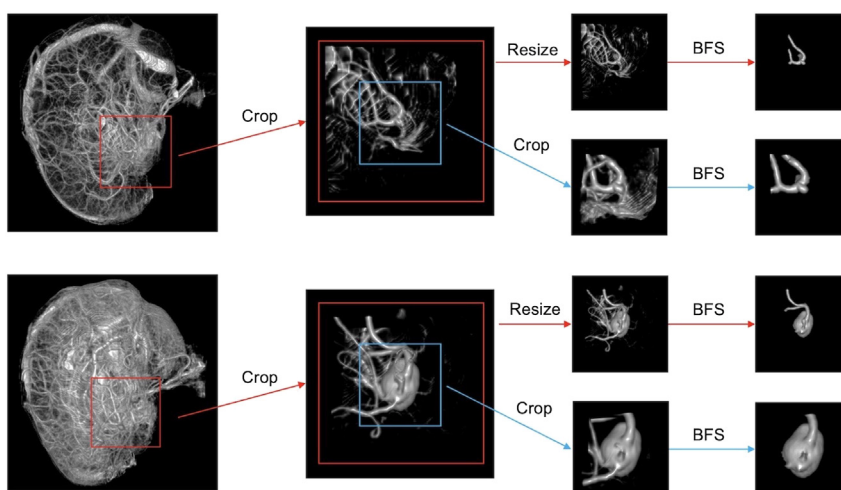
Two examples of cropping an IA and its cubic neighborhood from the 3D CTA data
